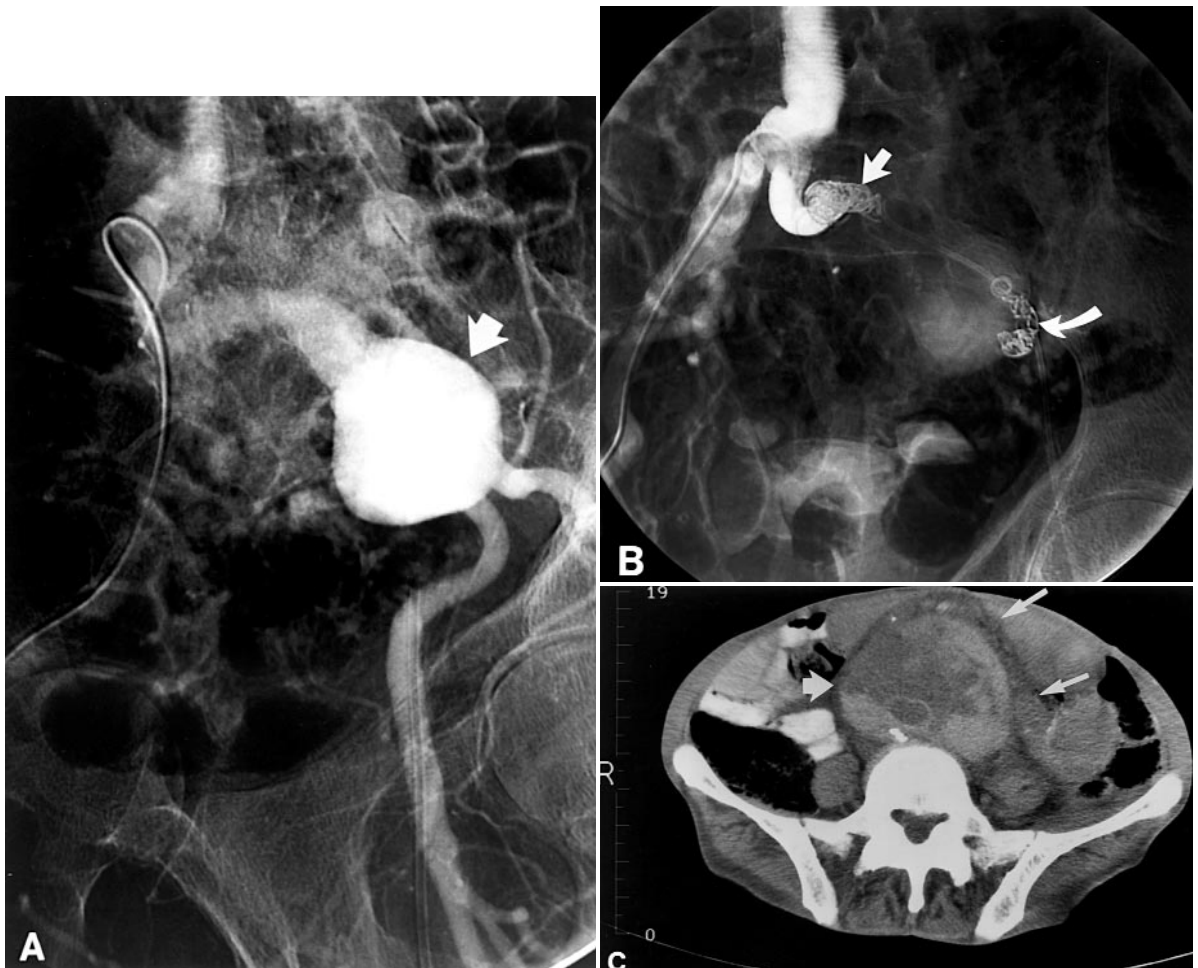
Large left common iliac aneurysm in a 74-year-old man at high risk. A, Arrow in arteriogram shows aneurysm. B, Straight arrow shows coils occluding proximal common iliac artery; curved arrow points to coils in the orifice of the hypogastric artery. The external iliac artery was ligated during the femorofemoral bypass. C, CT scan of the same patient 2 years later showing large intraabdominal hematoma as a result of rupture of the common iliac artery aneurysm. Arrows indicate the edge of the hematoma, which extends from the iliac artery to the renal arteries.
